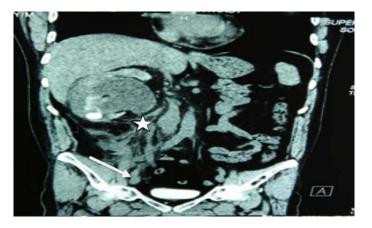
CT examination revealed right sided pyonephrosis (star) with inflamed mesentery in right lumbar region with intervening linear soft tissue bands consistent with mesenteric panniculitis.(arrow).
